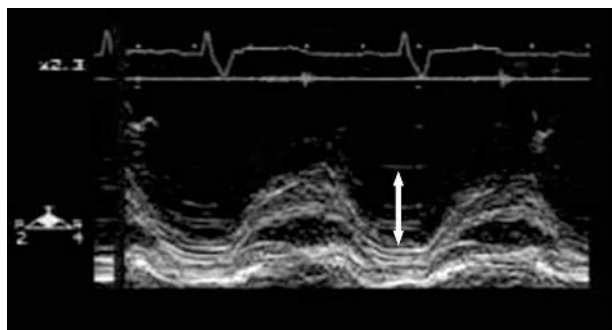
M mode echocardiogram of the lateral (free wall) tricuspid valve annulus. The height of the annular movement (white double arrow) is a surrogate marker of RV systolic function.
